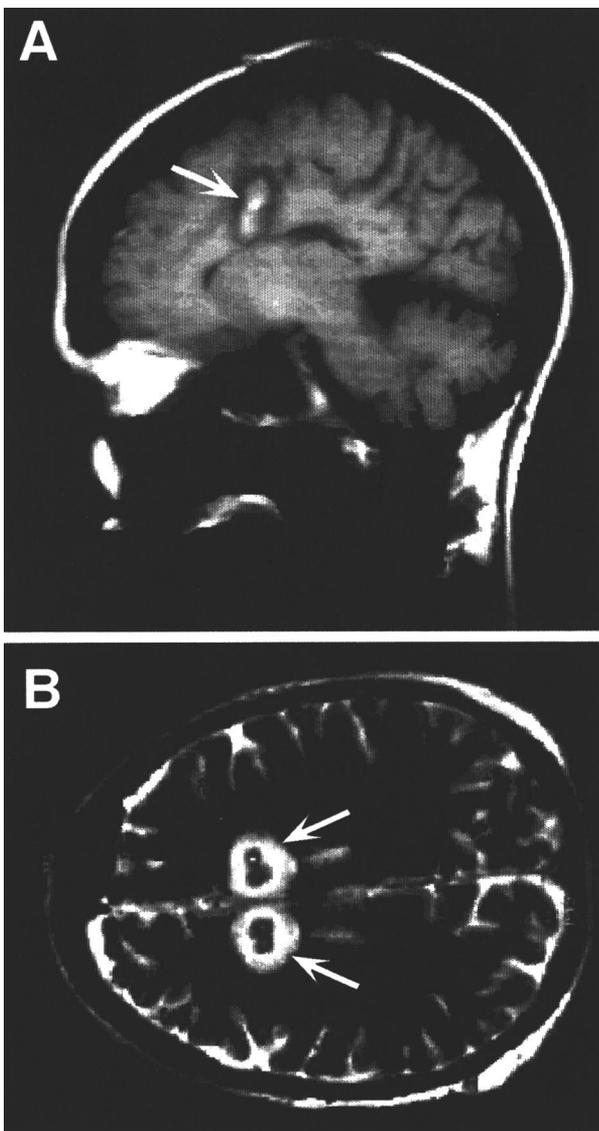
Structural MRI scan of M.T. after bilateral anterior cingulotomy. Arrows indicate lesion location. (A) T1-weighted parasagittal section 7 mm to left of midline showing extent and location of lesion. (B) T2-weighted axial section showing bilateral cylindrical lesions.
